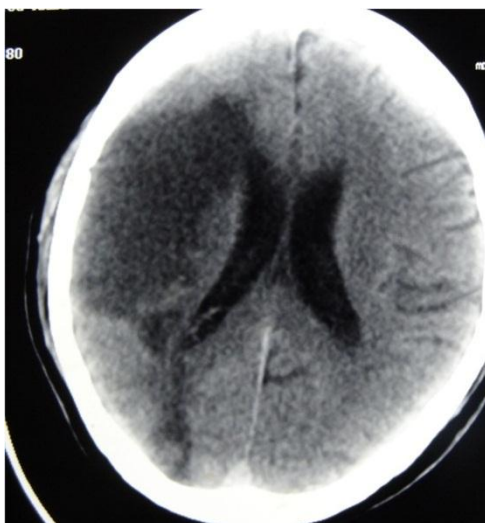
CT scan of brain showing large infarct involving right middle cerebral artery territory.
